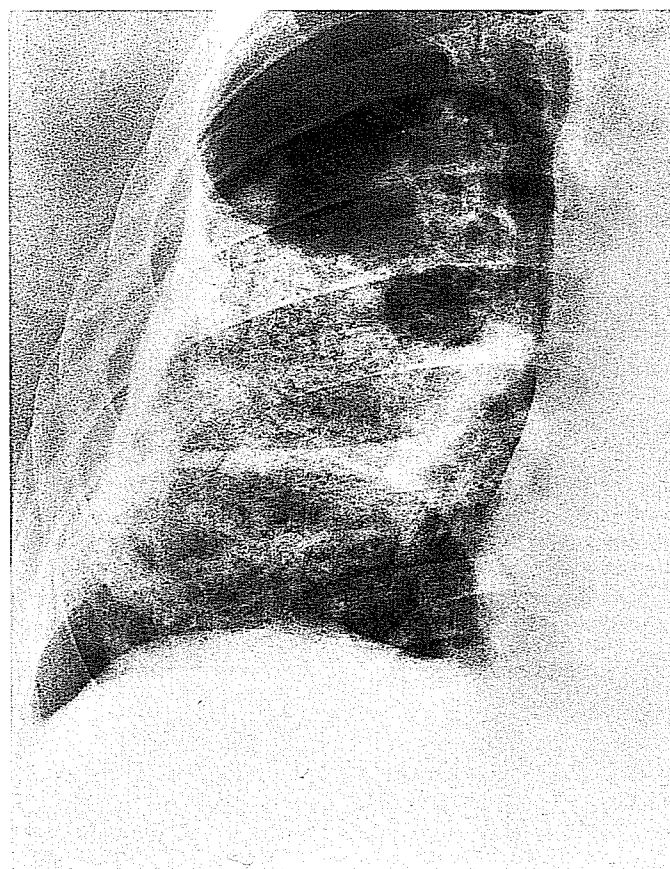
Pleural calcification. Localized view of right middle and lower zone shows sheetlike calcification. Laterally, where calcification is tangential to the x-ray beam, it is dense and homogeneous, but medially – where it is seen en face – it is more broken up and nodular. There is a 1 cm thick band of noncalcified pleural thickening along the lateral chest wall.
